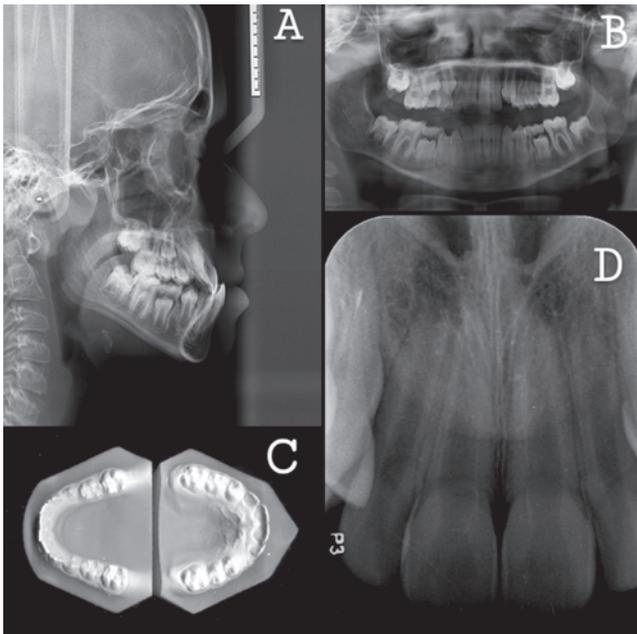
Pre-treatment files: A) Lateral cephalogram; B) Panoramic radiograph; C) Study casts; D) Periapical radiograph before palatal suture disjunction.
